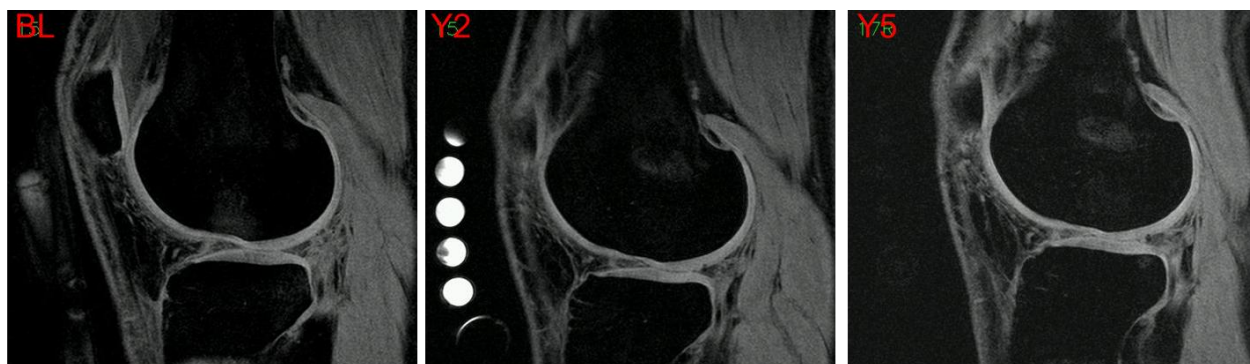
MR images of the femoropatellar joint at baseline (BL), 2 years (Y2) and 5 years (Y5) after ACL injury
